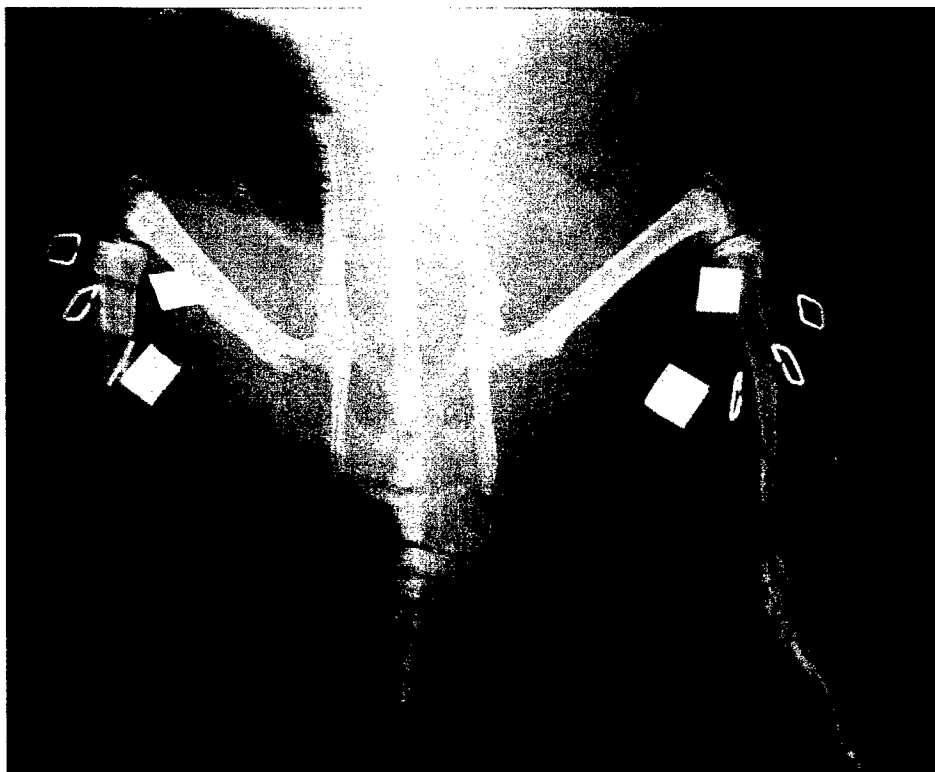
Radiograph of 5.0 x 5.0 x 1.5 mm DU(Ti) fragments on day of implantation.
